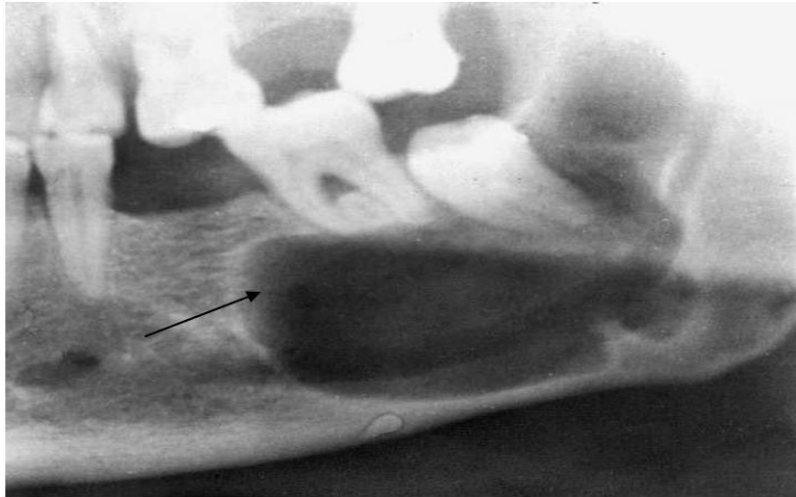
Radiograph of an odontogenic keratocyst with scalloped margins.
